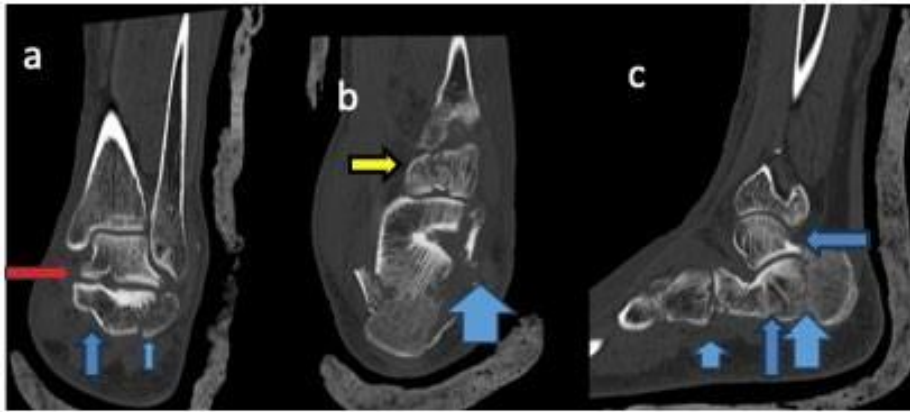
CT images (MPR) in coronal (a), axial (b), and sagittal planes (c), showing left calcaneus with multiple intra-articular fractures
